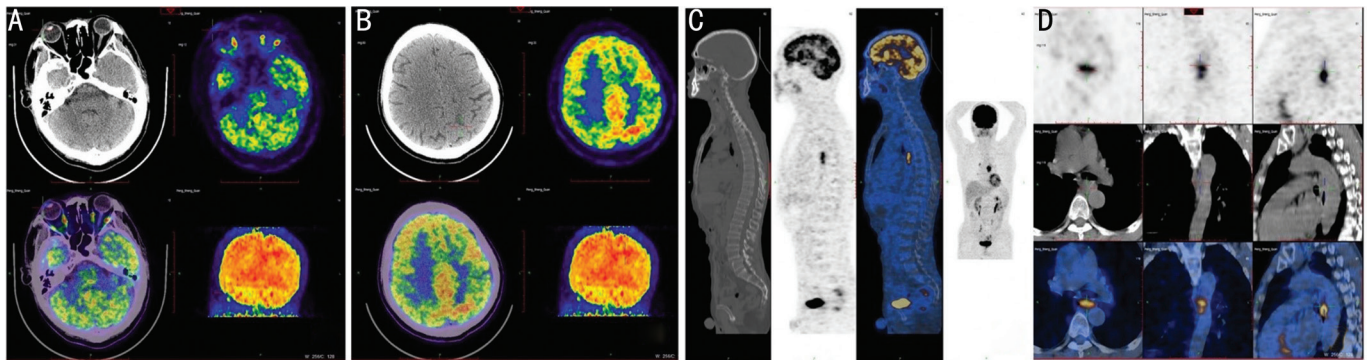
Imaging manifestations of the patient CT shows a high-density shadow in the right anterior segment (A). PET/CT revealing the high uptake of FDG in the anterior chamber space of the right eye (A), the middle esophagus (C, D) and left parietal lobe of the brain (B). CT: Computed tomography; PET/CT: Positron emission tomography-computed tomography; FDG: Fluorodeoxyglucose.
